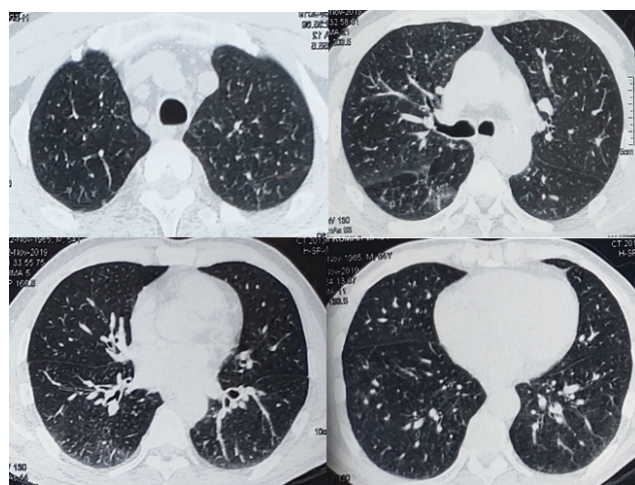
HRCT after 9 months showing complete resolution of lung opacities
